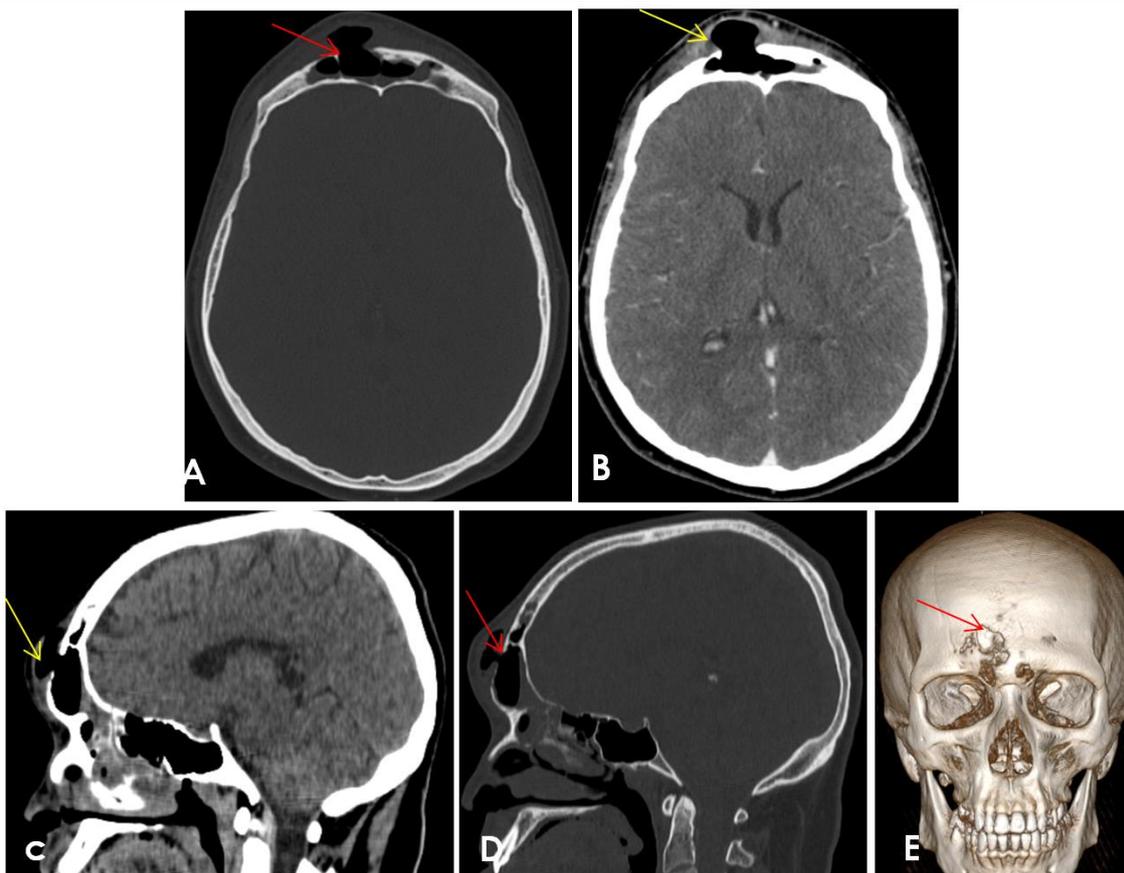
Cranio-facial CT in axial (A, B, C) and sagittal (D and E) sections with VRT reconstructions (F): a right frontal collection enhanced peripherally by contrast and containing air bubbles (yellow arrow), with anterior bone defect (red arrow), but no abnormality in the brain parenchyma
